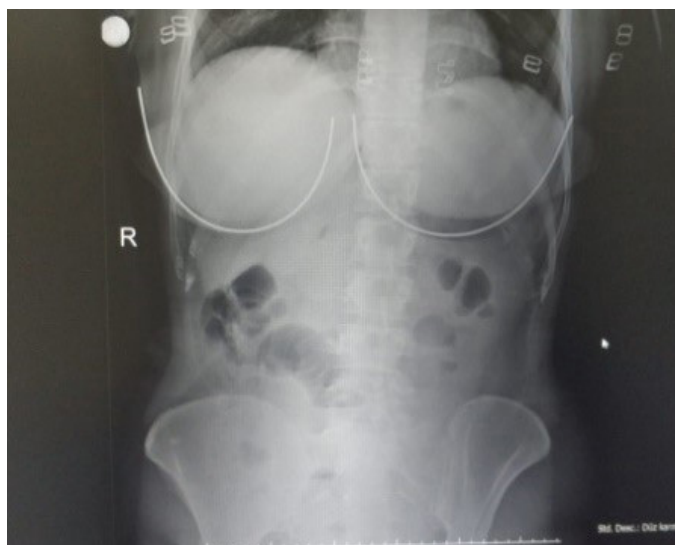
2nd day of hospitalization, standing direct abdominal X-ray
